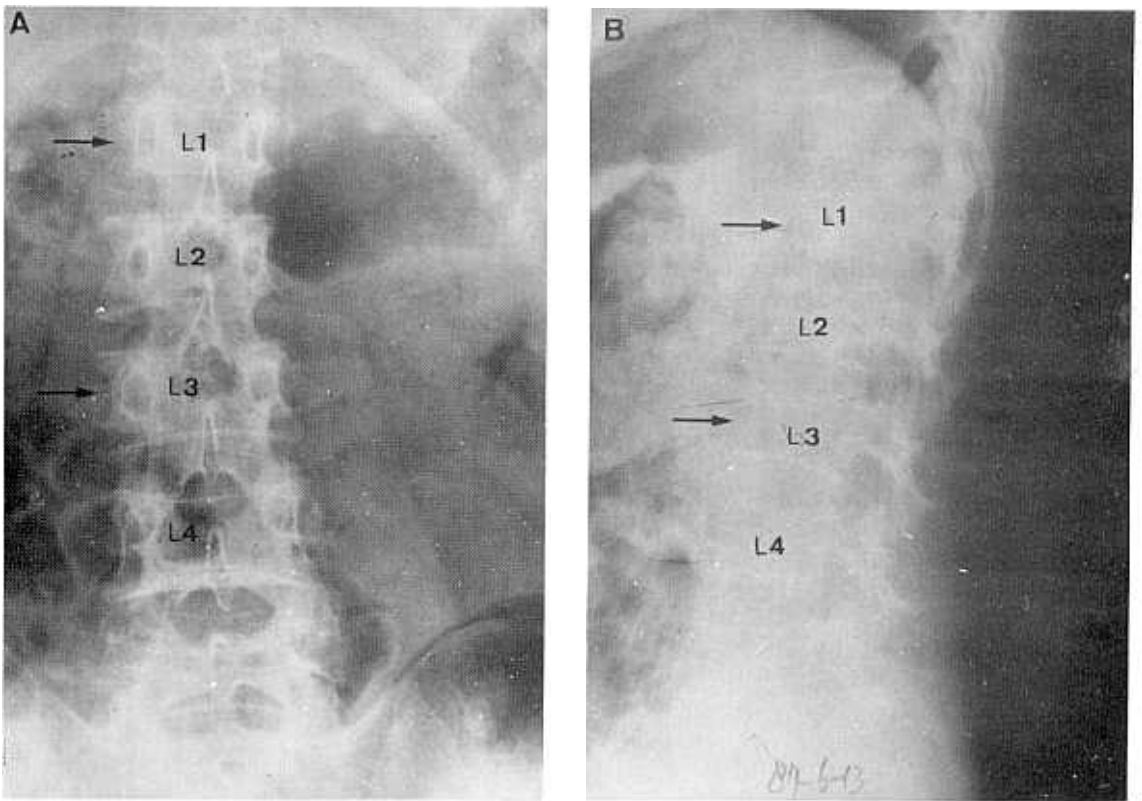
Plain X-ray of the lumbar spine severe osteoporosis on the entire spine with compression fracture of L1 and L3 spine.
